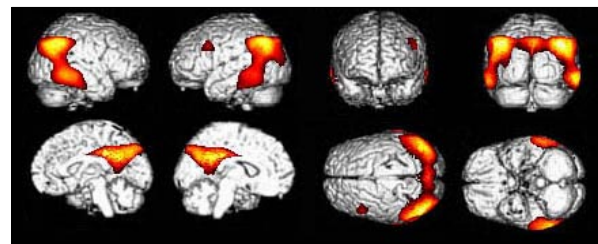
Typical metabolic decreased areas in AD. The parietotemporal, posterior cingulate and precuneus areas have regions with significantly reduced glucose metabolism compared with normal controls. These areas are clearly shown by surface rendered MR images.
